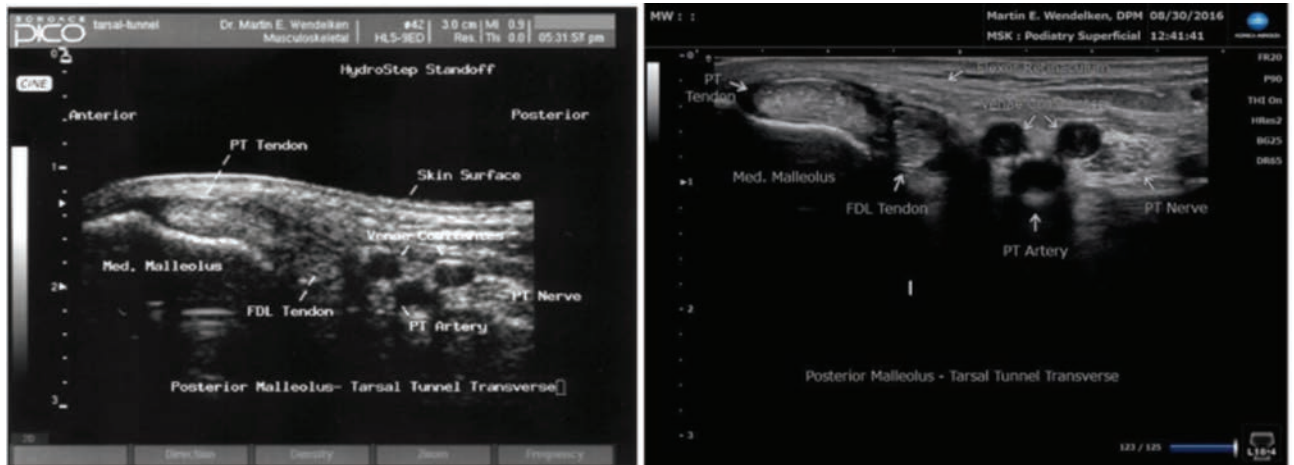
Above left—Ultrasound scan of a transverse section of the tarsal tunnel at 8 MHz while the same scan of the same tarsal tunnel (above right) on today's high resolution ultrasound at 18 MHz. Note the clarity of the structures including the PT and FDL tendons, PT artery with vena comitantes, PT nerve and even the flexor retinaculum.
